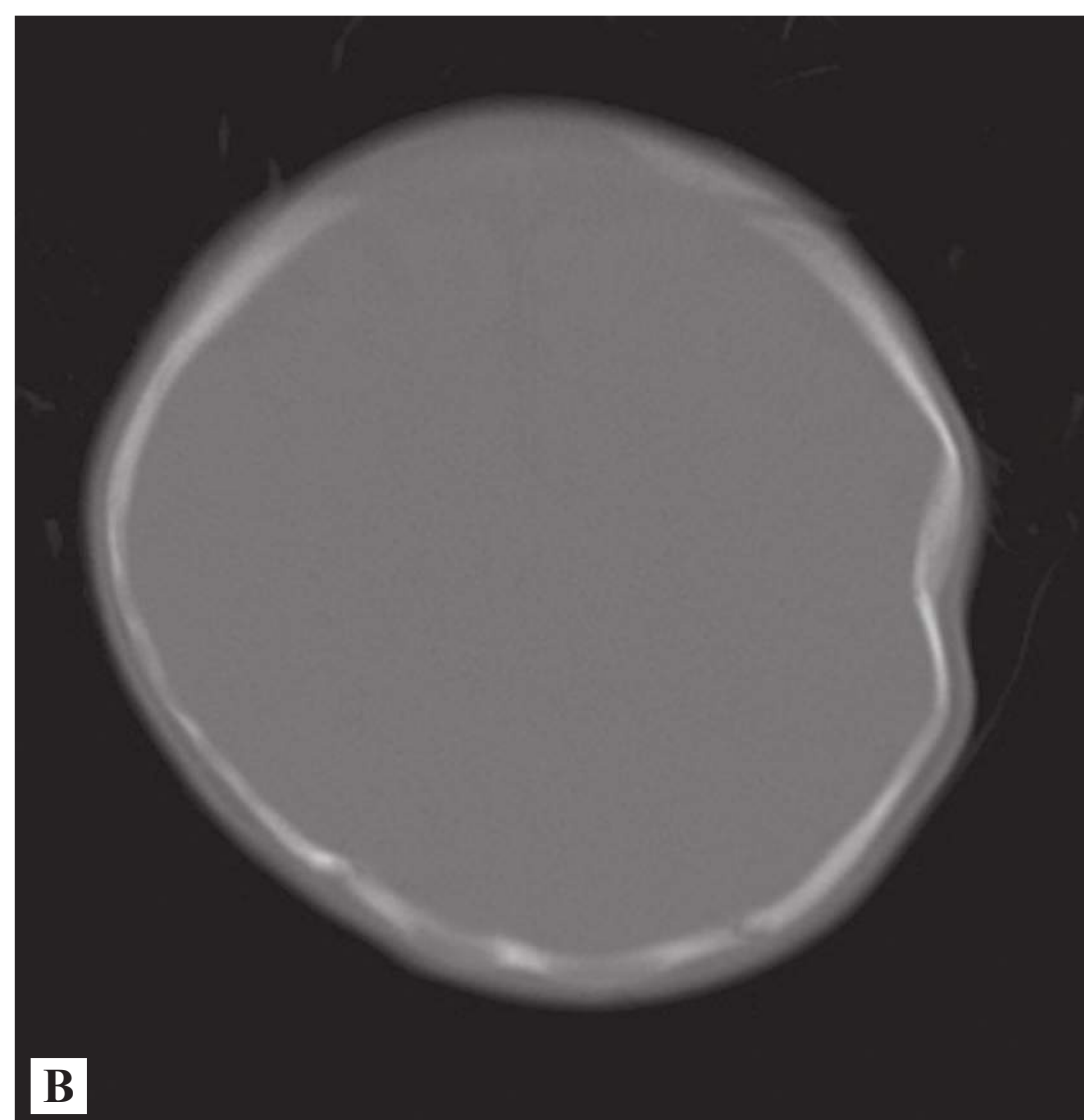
■ Ping Pong Ball Skull Fracture. (A) Akin to the greenstick fracture, a ping pong ball fracture occurs when a newborn or infant's relatively soft skull is indented by the corner of a table or similar object without causing a frank break in the bone. (B) CT demonstrates the ping pong ball effect. (Photo contributor: Johnny Wei, BS.)
